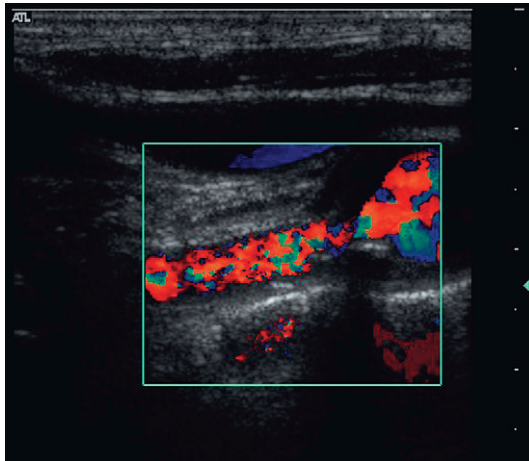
A stenosis at the origin of the vertebral artery with marked turbulence shown on colour Doppler.
